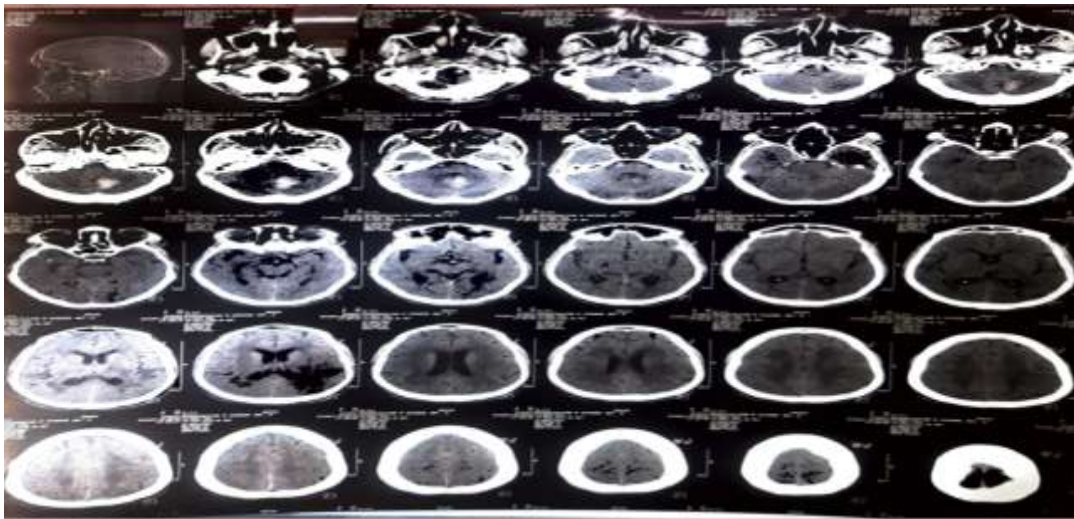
CT SCAN HEAD (NOTE HYPER DENSITY IN BILATERAL CEREBELLAR HEMORRHAGE)
